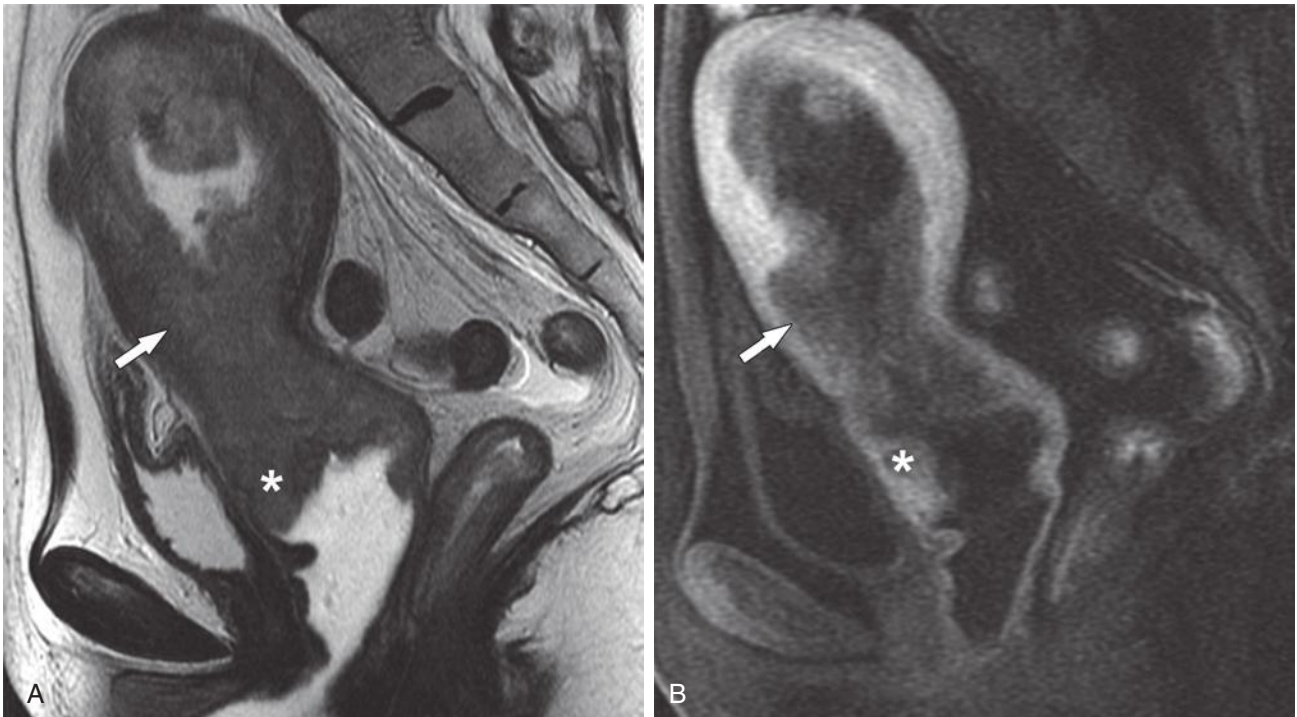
Stage IIIB endometrial cancer. Sagittal T2-weighted (A) and sagittal dynamic gadolinium-enhanced fat-saturated T1-weighted (B) images show an irregular endometrial tumor with greater than 50% myometrial invasion (arrows) and extension into the cervix and upper vagina (asterisks).
